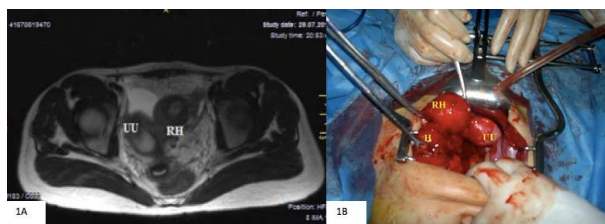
A. Magnetic resonance imaging showing the unicornuate uterus (UU) and the rudimentary horn (RH) B. The unicornuate uterus (UU), the rudimentary horn (RH), and the hematosalpinx (H)
